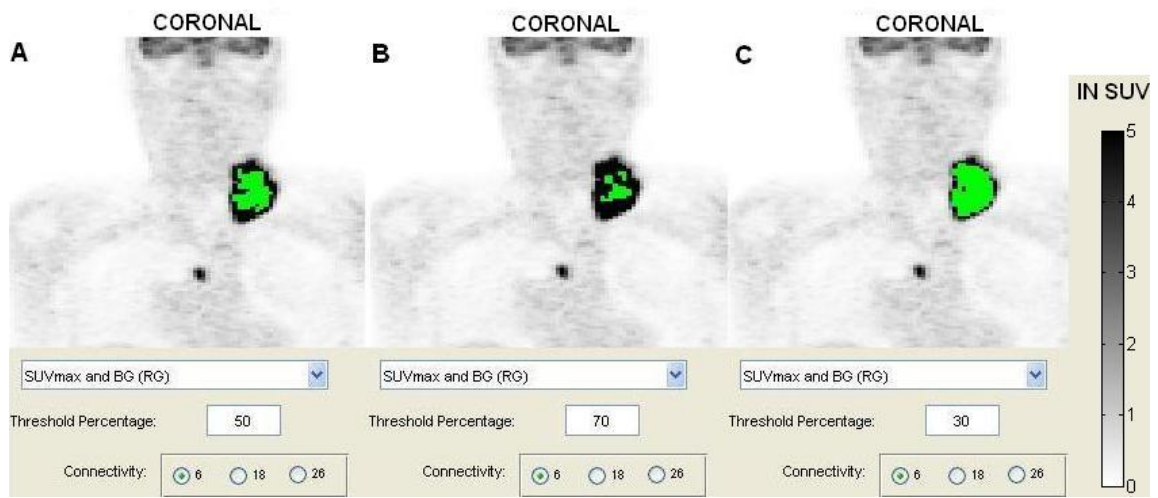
Visual Display of SUV_{max} and Background Segmentations
